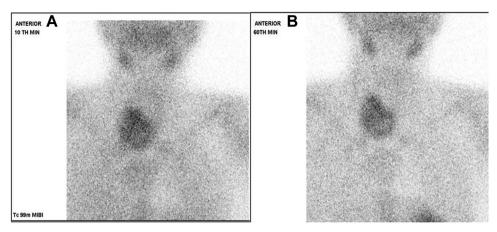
PTH scintigraphy showing tracer accumulation in the lesion noted in the right lower pole of thyroid in the initial image at 10 minutes (*A*), which persists in the delayed image at 60 minutes (*B*). PTH = parathyroid hormone.
